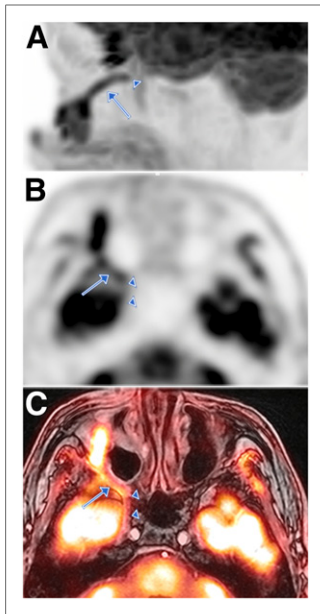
CN V2 (maxillary nerve, infraorbital branch) involvement in patient with recurrent squamous cell carcinoma of nose after multiple excisions, including total rhinectomy and postoperative radiotherapy. (A) Sagittal maximum-intensity-projection PET image shows ^{18}F -FDG-avid tumor extension along course of right CN V2, originating from tumor recurrence in right cheek, tracking along infraorbital nerve in infraorbital canal (arrow), and entering inferior orbital fissure into region of right pterygopalatine fossa (arrowhead). (B and C) Axial PET (B) and axial fused PET/MR (C) images show PNS along CN V2 past pterygopalatine fossa (arrow) intracranially through right foramen rotundum (arrowheads) and into inferior cavernous sinus. Tumor management required aggressive local excision.
